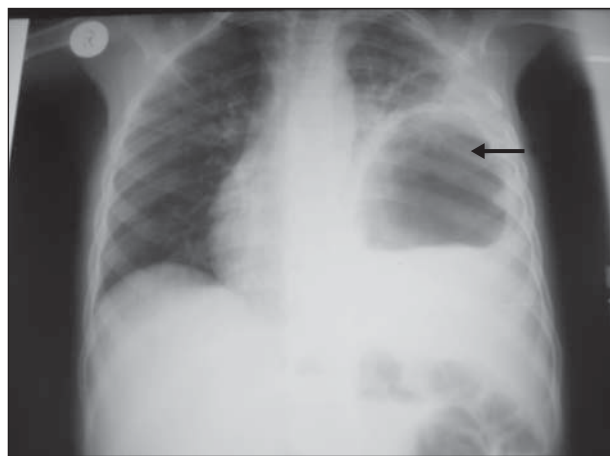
Chest radiography on presentation showing an encapsulated structure (arrow) in the left lower zone with an air-fluid level.
